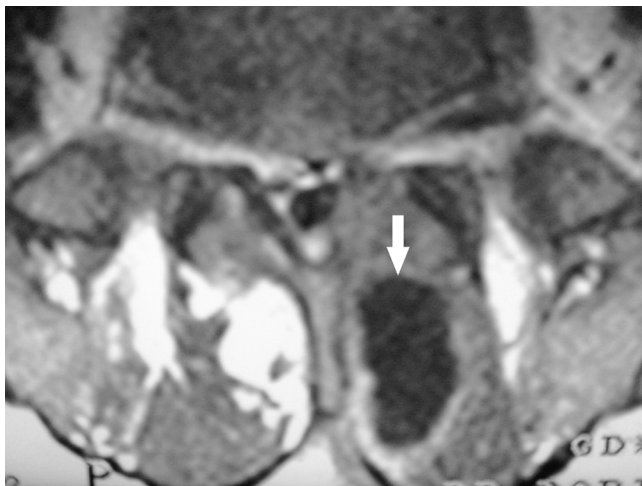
Axial T1-weighted magnetic resonance image with contrast medium demonstrating a ring-enhanced, hypointense ellipsoid lesion with a central hypointense nidus in the left paravertebral soft tissue at the level of L-4.
